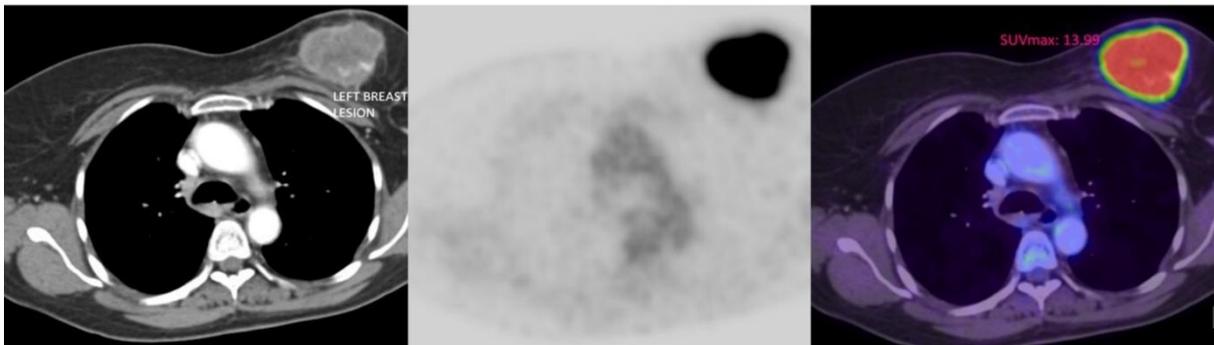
CT(7a), PET(7b), and fusion(7c) images with SUV max uptake of 13.99 in the left breast lesion.
